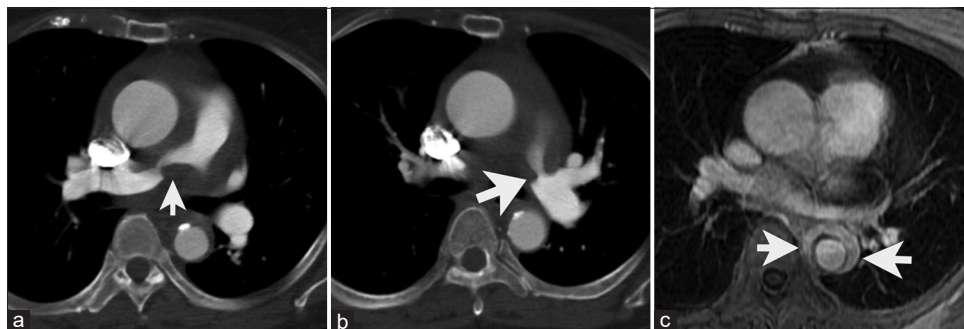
A 68-year-old female presented with progressive dyspnea on exertion, exertional dizziness, fatigue, and extremity weakness. Computed tomography angiogram demonstrating (a) high-grade stenosis at the origin of the right pulmonary artery (white arrow) and (b) circumferential stenosis of the proximal left pulmonary artery (white arrow). MR angiogram showing (c) gadolinium-enhancing adventitial thickening of the descending thoracic aorta (white arrows).
